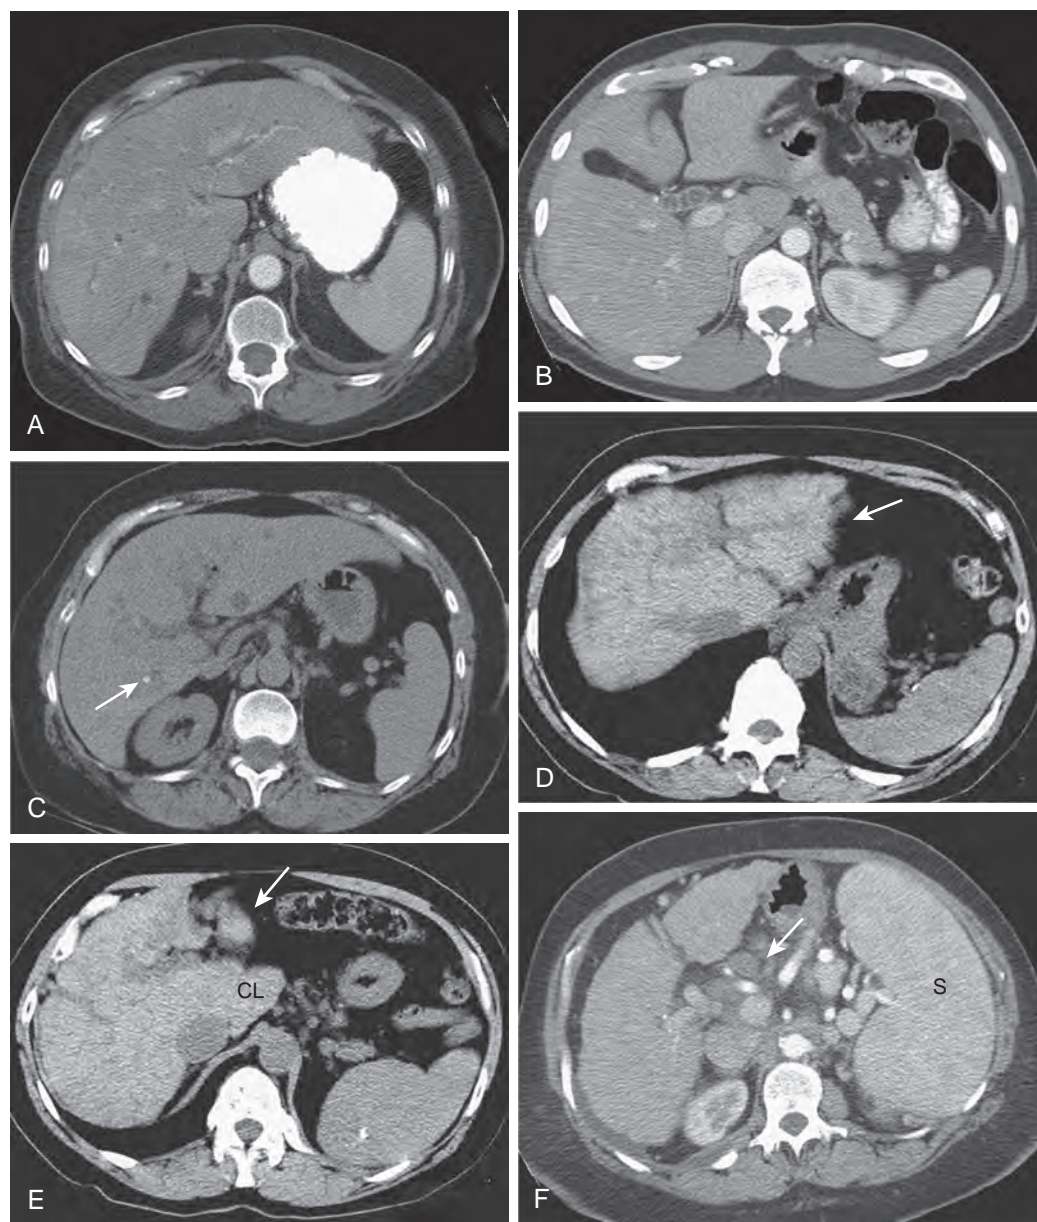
PSC: CT findings.
